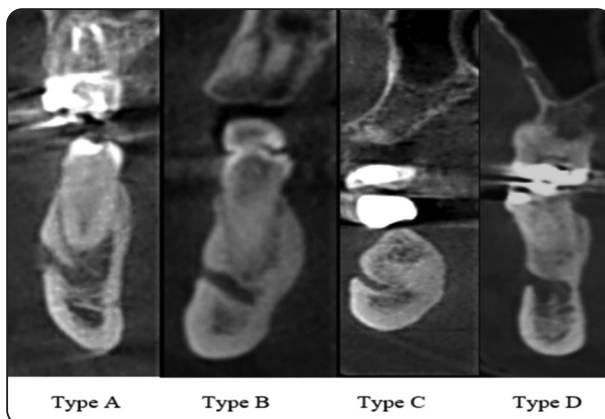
CBCT, cross-sectional views showing the shapes (types) of the mandible at the mental foramen (MF).
